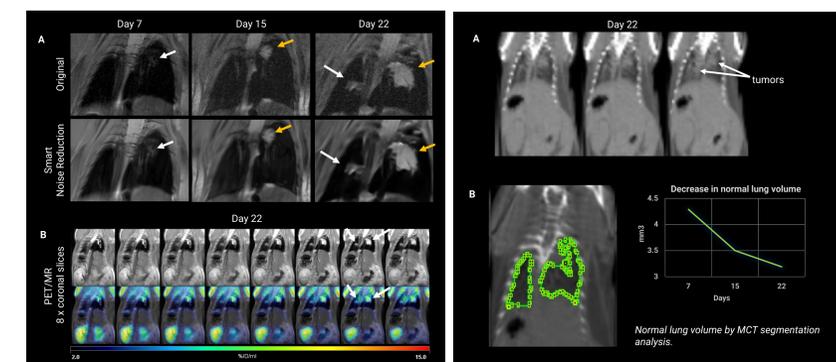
MRI *in vivo* detection of CT-26 tumor margin and tumor-associated inflammation (A). PET/MRI fusion of lung tumor inflammation and tumor tissue metabolic activity (B).
